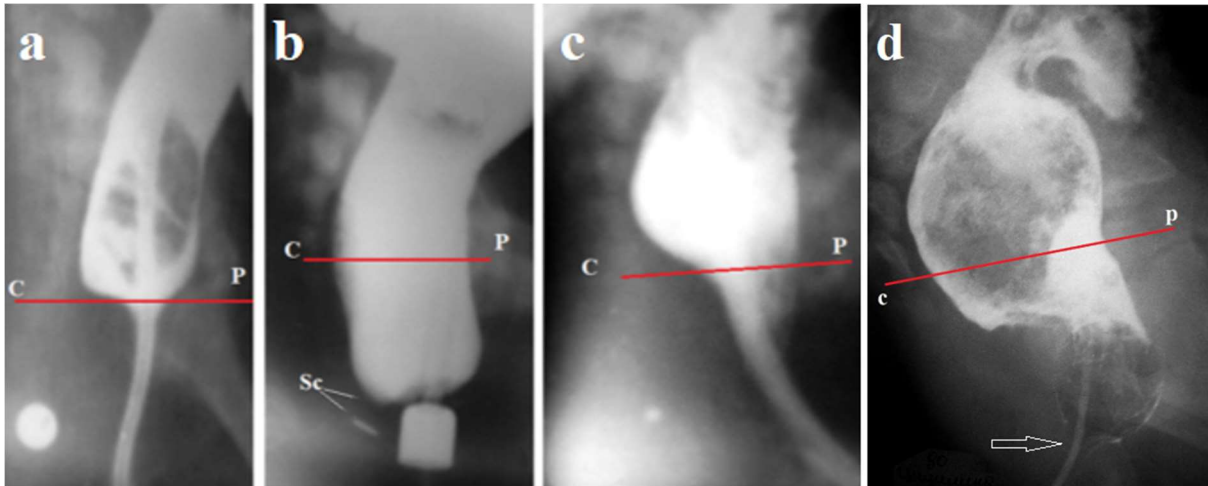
Anatomy and physiology of the ARMs with visible fistula. (a) Lateral radiograph of the anorectal area of a 9-month-old patient, performed after barium was introduced into the rectum through a catheter passed through the ectopic orifice. A round thumbtack was glued to the anal dimple. The sphincters of the anal canal located caudal to the pubococcygeal line (red) have contracted around the catheter, preventing barium leakage. (b) The same patient at 1.5 years of age. Radiograph taken during an attempted defecation. A wide opening of the anal canal occurred. The distance from the wall of the IAS to the thumbtack in the anal dimple (Sc) is 4 mm (the true diameter of the marker near the ectopic anus is 1.6 cm). The subcutaneous part of the EAS is in the subcutaneous fat tissue in the space between the skin and the IAS. As can be seen in Figure (a), its absence around the ectopic anus does not affect the function of barium (feces) retention. (c) During the introduction of barium through the endotracheal tube, relaxation of the IAS occurred, resulting in barium entering from the rectum into the upper part of the anal canal in front of the enema tip. At the same time, the posterior portion of the IAS was pressed against the tube due to contraction of the PRM. At the same time, the deep and subcutaneous parts of the EAS also contracted to prevent barium leakage. This is the radiographic equivalent of the rectoanal inhibitory reflex [12]. (d) A 7-year-old boy with congenital anal stenosis, who was treated with bougienage in early childhood. He complains about constipation and soiled underwear. A Foley catheter was inserted into the rectum, through which approximately 200 ml of barium was insufflated. Approximately 5 cm³ of air was injected into the balloon. During an attempt to remove the catheter, the balloon became lodged above the anus (arrow).
